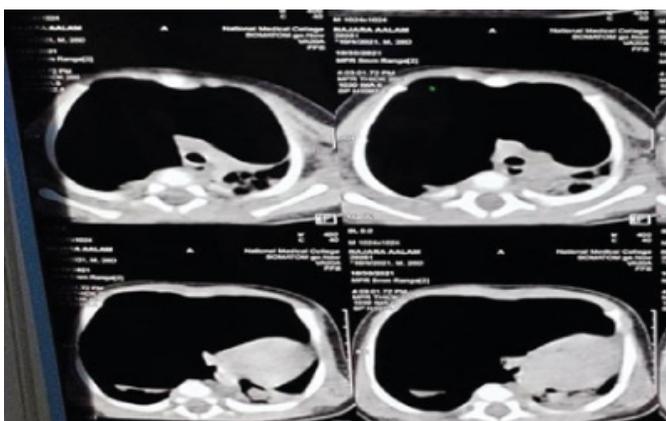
Computed tomography scan of 19-days infant with congenital pulmonary malformations
